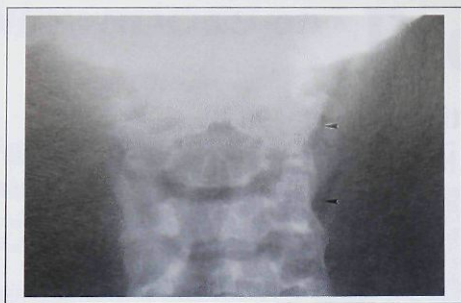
Anteroposterior cervical radiograph, revealing subcutaneous cervical emphysema (arrowheads).
